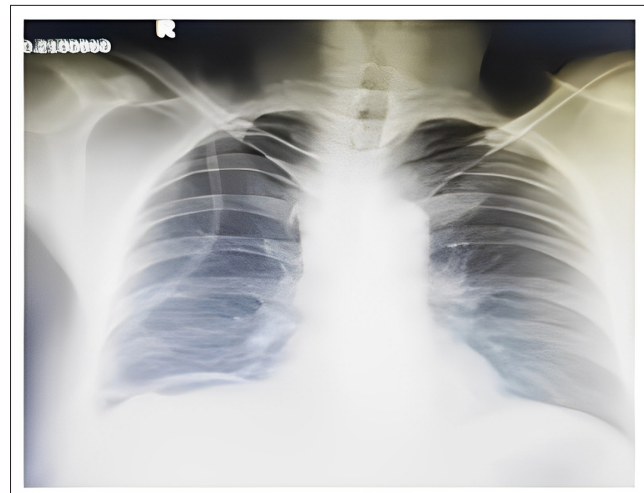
Erect abdomen x-ray free air under the right dome of diaphragm.
